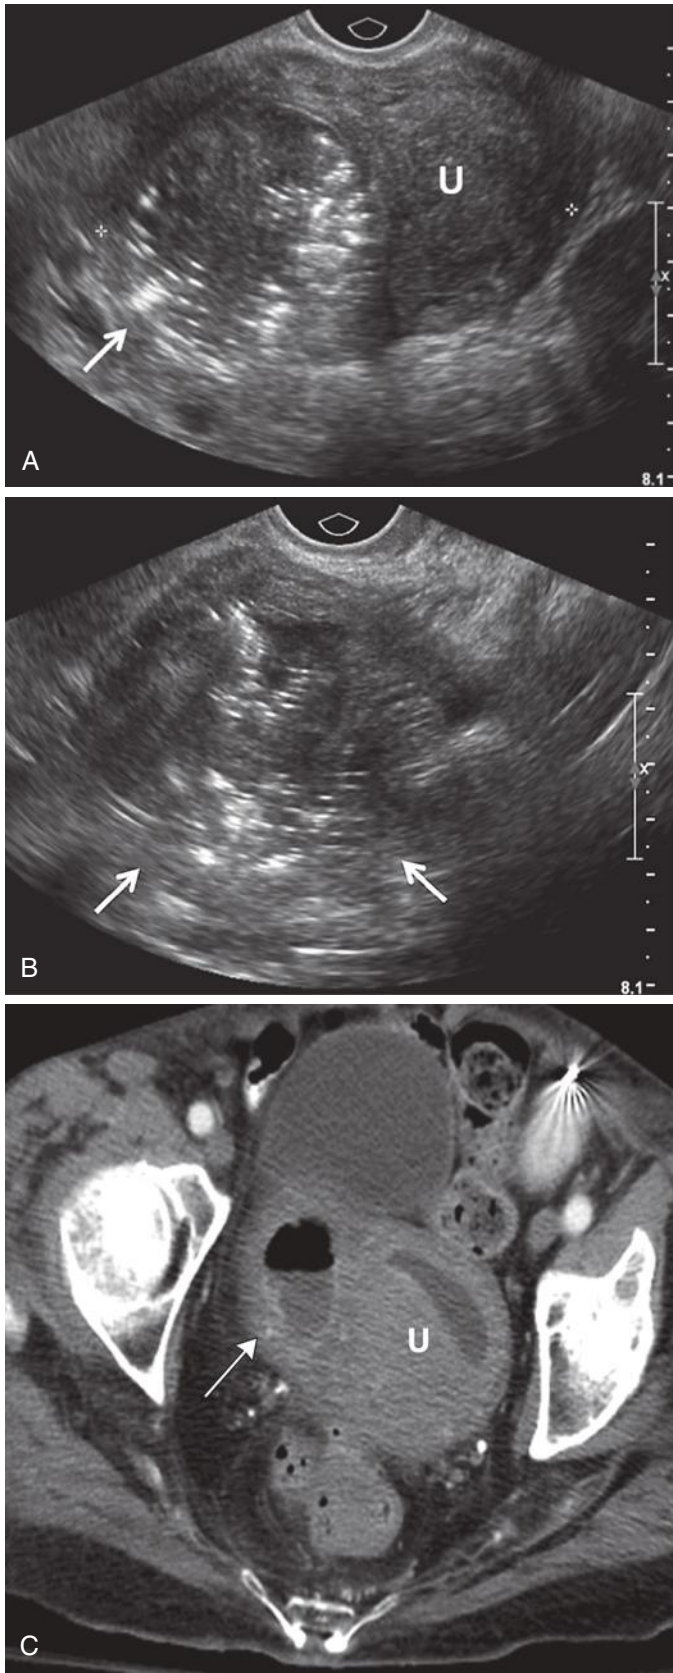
Actinomycosis. Transvaginal sonographic images of the right adnexa (A and B) in an 82-year-old woman presenting with abdominal discomfort. Note a large mass (*arrows*) adjacent to the uterus (U) containing numerous brightly echogenic foci suggesting microbubbles of gas. Contrast-enhanced axial computed tomographic scan (C) confirms the presence of a large gas-containing abscess (*arrow*) in the right adnexa adjacent to the uterus (U). A fistula to the bowel was found at surgery and cultures grew *Actinomyces*. (Images courtesy of Dr. Margarita Revzin, Yale University School of Medicine, New Haven, CT.)
